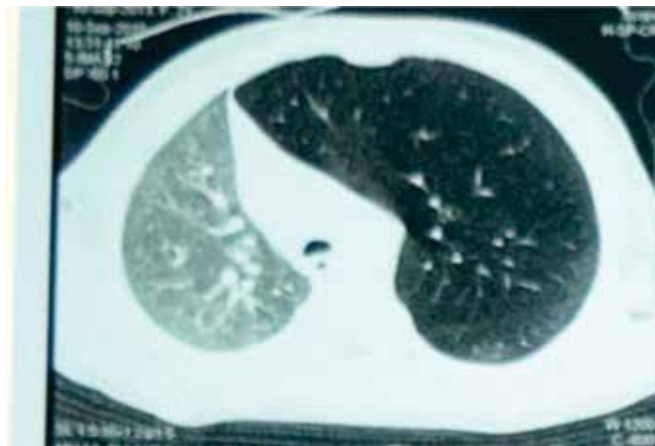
Computed tomography showing hyperlucent left lung with contralateral mediastinal shift.
